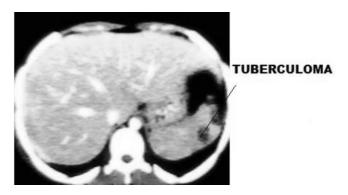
CT images showing a hypodense area in spleen suggesting tuberculoma.
